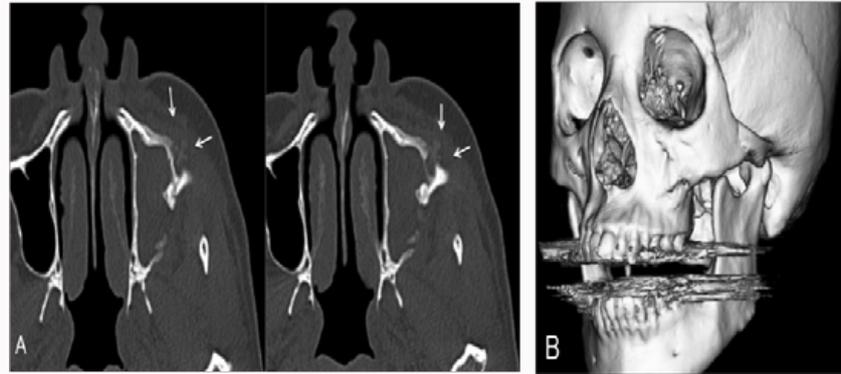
Computed tomography images. (A) Axial soft tissue window image showing a cystic lesion, extending from the left maxillary alveolar area to the maxillary sinus. (B) The fracture had sufficiently recovered; however, the zygomaticomaxillary bone surrounding the plate was absorbing it.
